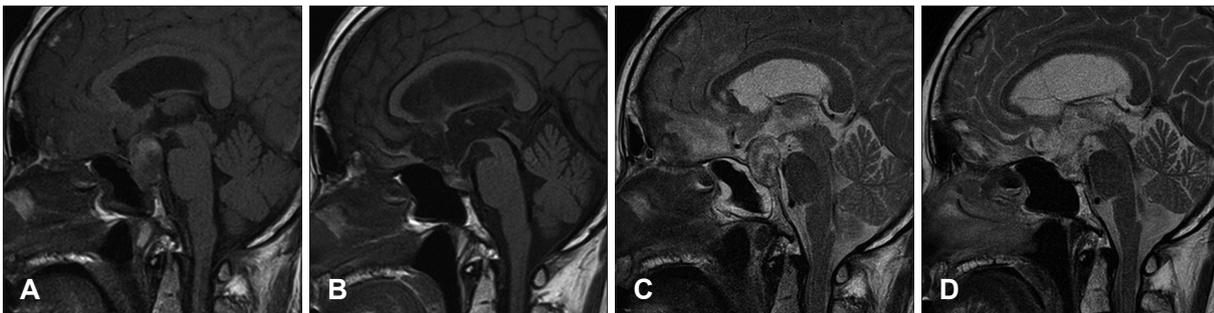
Initial (A, C) and follow-up (B, D) MRI of the brain. T1- and T2-weighted sagittal images (B, D) four months after head injury reveal total regression of pre-existing pituitary macroadenoma after pituitary apoplexy.
